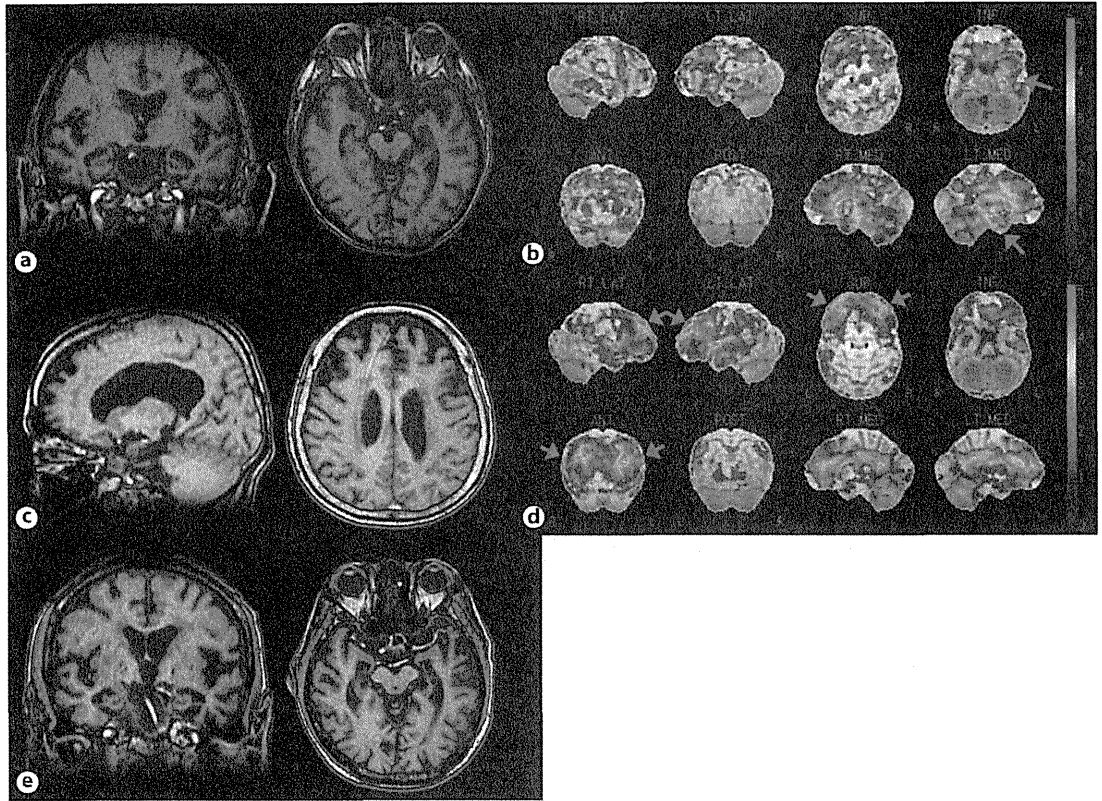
Imaging findings in individual cases of PiB-negative dementia. a In MRI scans (case 1), there is a dilatation of the temporal groove and inferior horn of the lateral ventricle and atrophy of the temporal pole and anterior medial temporal lobe, all with left-sided dominance. b An FDG- PET image (case 3) showing hypometabolism of the medial temporal lobe with left-sided dominance (arrow). c MR images (case 5) showing marked atrophy of both frontal lobes. d FDG-PET images of the same case showing hypometabolism of both frontal lobes (arrow). e MR images (case 7) showing atrophy of both hippocampi with enlarged inferior horns of the lateral ventricles.
